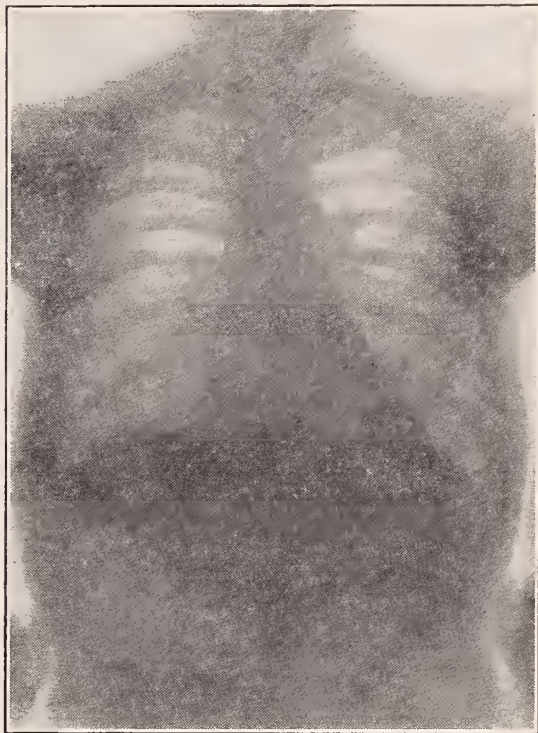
x-Ray picture of chest on readmission.
